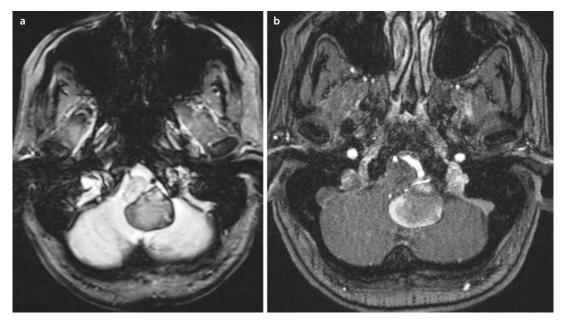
Axial MRI. The T2-fl2d image shows the thrombotic part of the aneurysm as well as the space-occupying effect inside the cerebellum with consecutive
